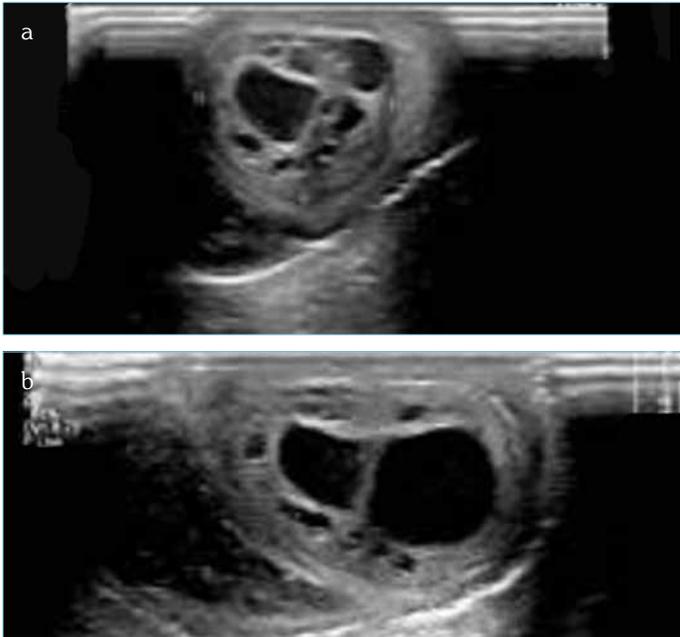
a, b. Ultrasound image of the left testis scrotum. A complicated cystic lesion (teratoma), whose contours could not be differentiated from the left testicular parenchyma, contained 15×10 mm septations
